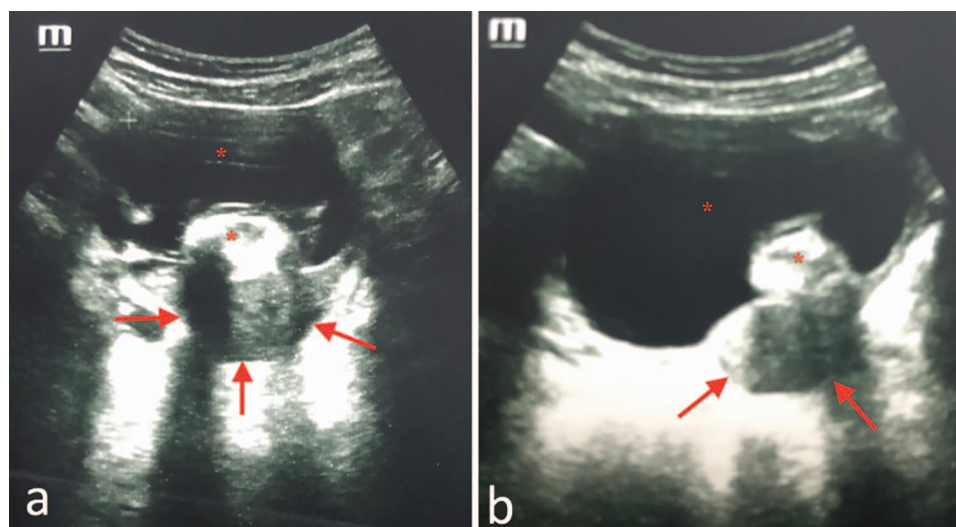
Sonographic image of the left adnexal mass of Case 2. Dermoid cyst (*); endometrioma (arrow).
